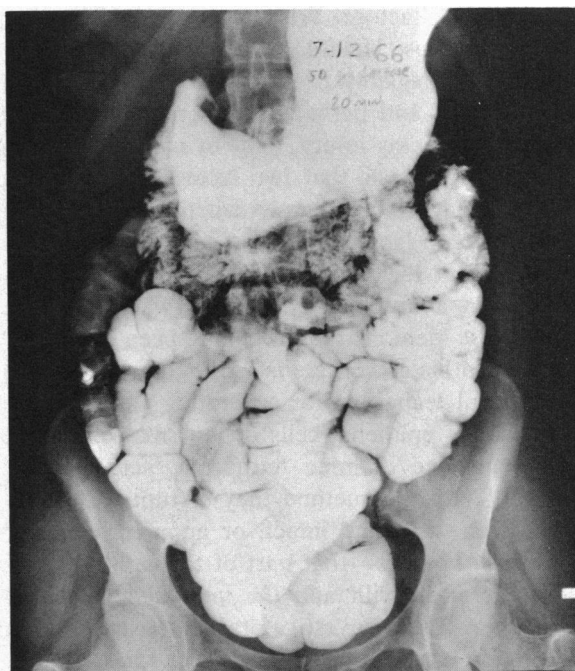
X-ray film with barium containing 50 gm of lactose.
